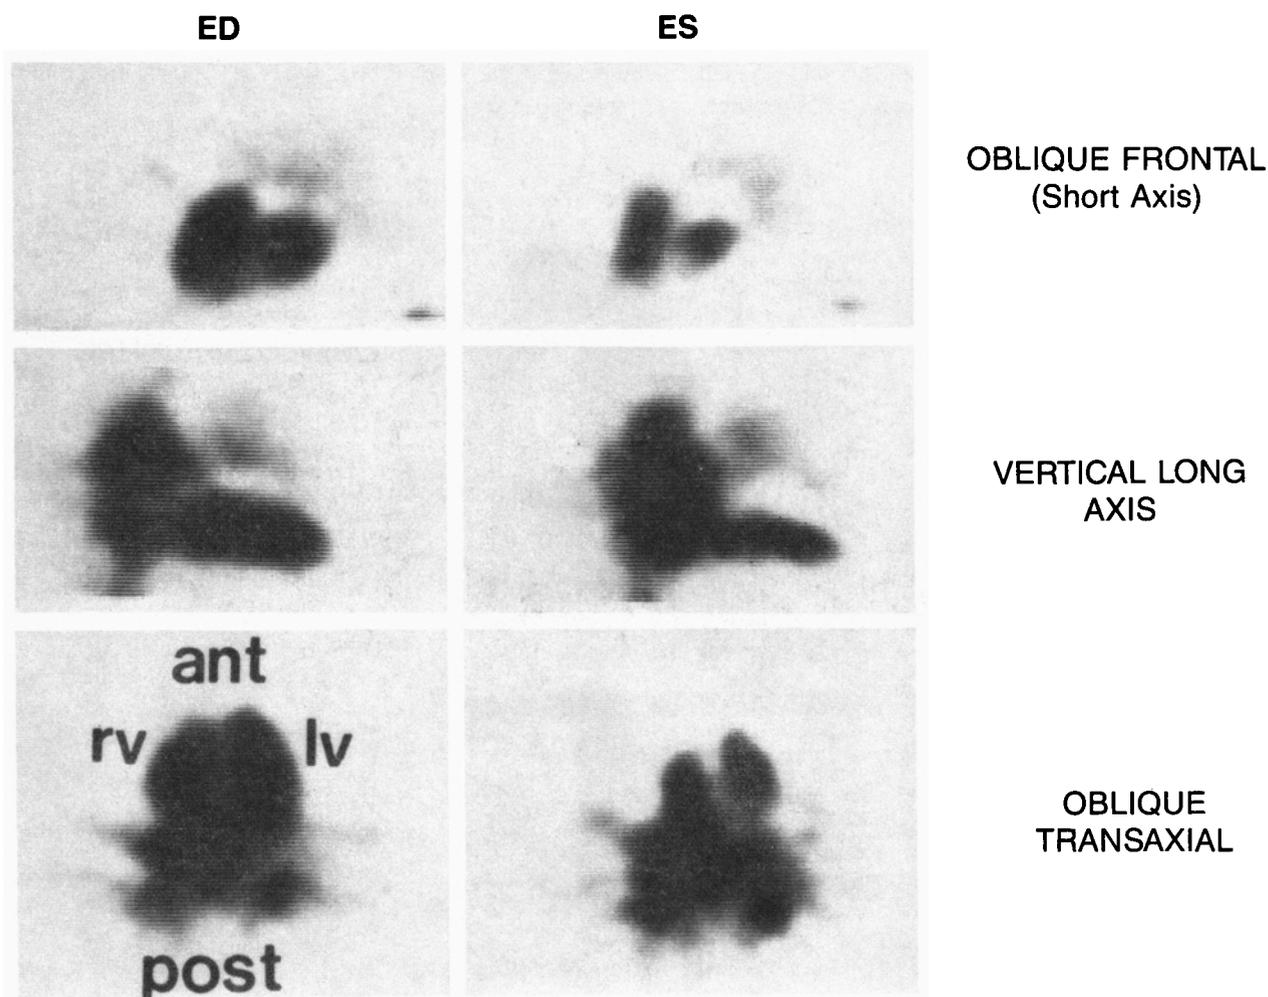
Dual gated GSPECT oblique mid-ventricular slices (12 mm thick) of a normal heart. ED = end diastole, ES = end systole, Ant = anterior, Post = posterior.
